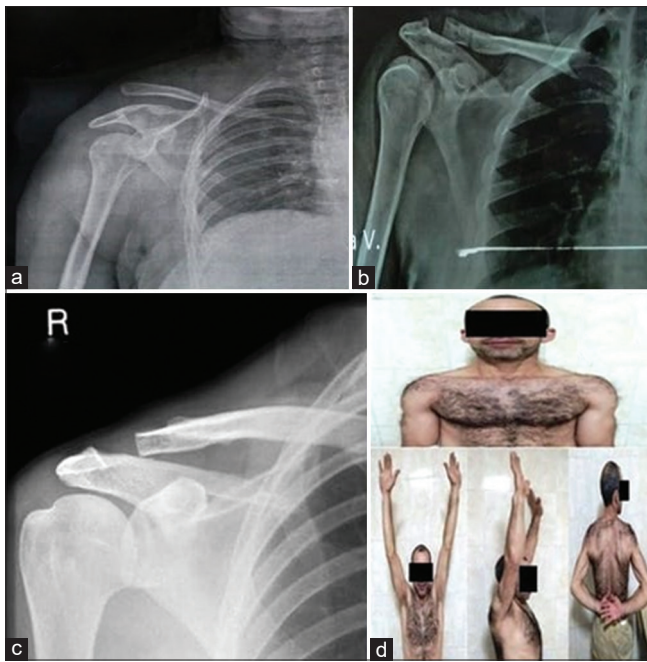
(a) Preoperative X-ray showing type V acromioclavicular dislocation, (b) Immediate postoperative X-ray with reduced acromioclavicular joint (ACJ), (c) Eight months last follow-up X-ray without subluxation and (d) range of motion. The patient's coracoclavicular distance returned to normal after the modified Weaver–Dunn surgery was performed on his right ACJ, as seen on serial X-rays taken at intervals
